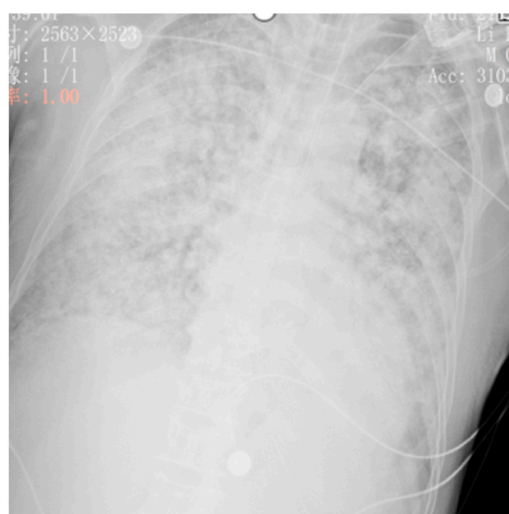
Chest X-ray captured on the first day of admission.
